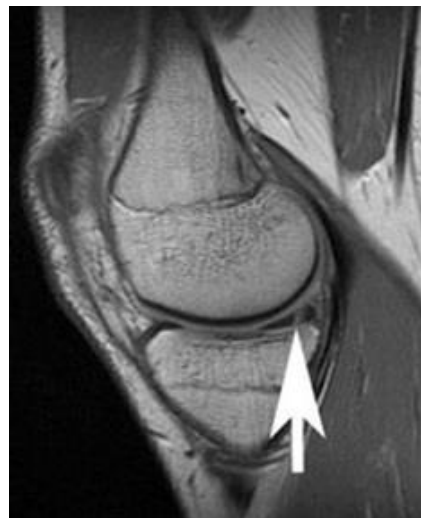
Sagittal MRI image shows a vertical tear in the posterior horn of the medial meniscus (white arrow).
